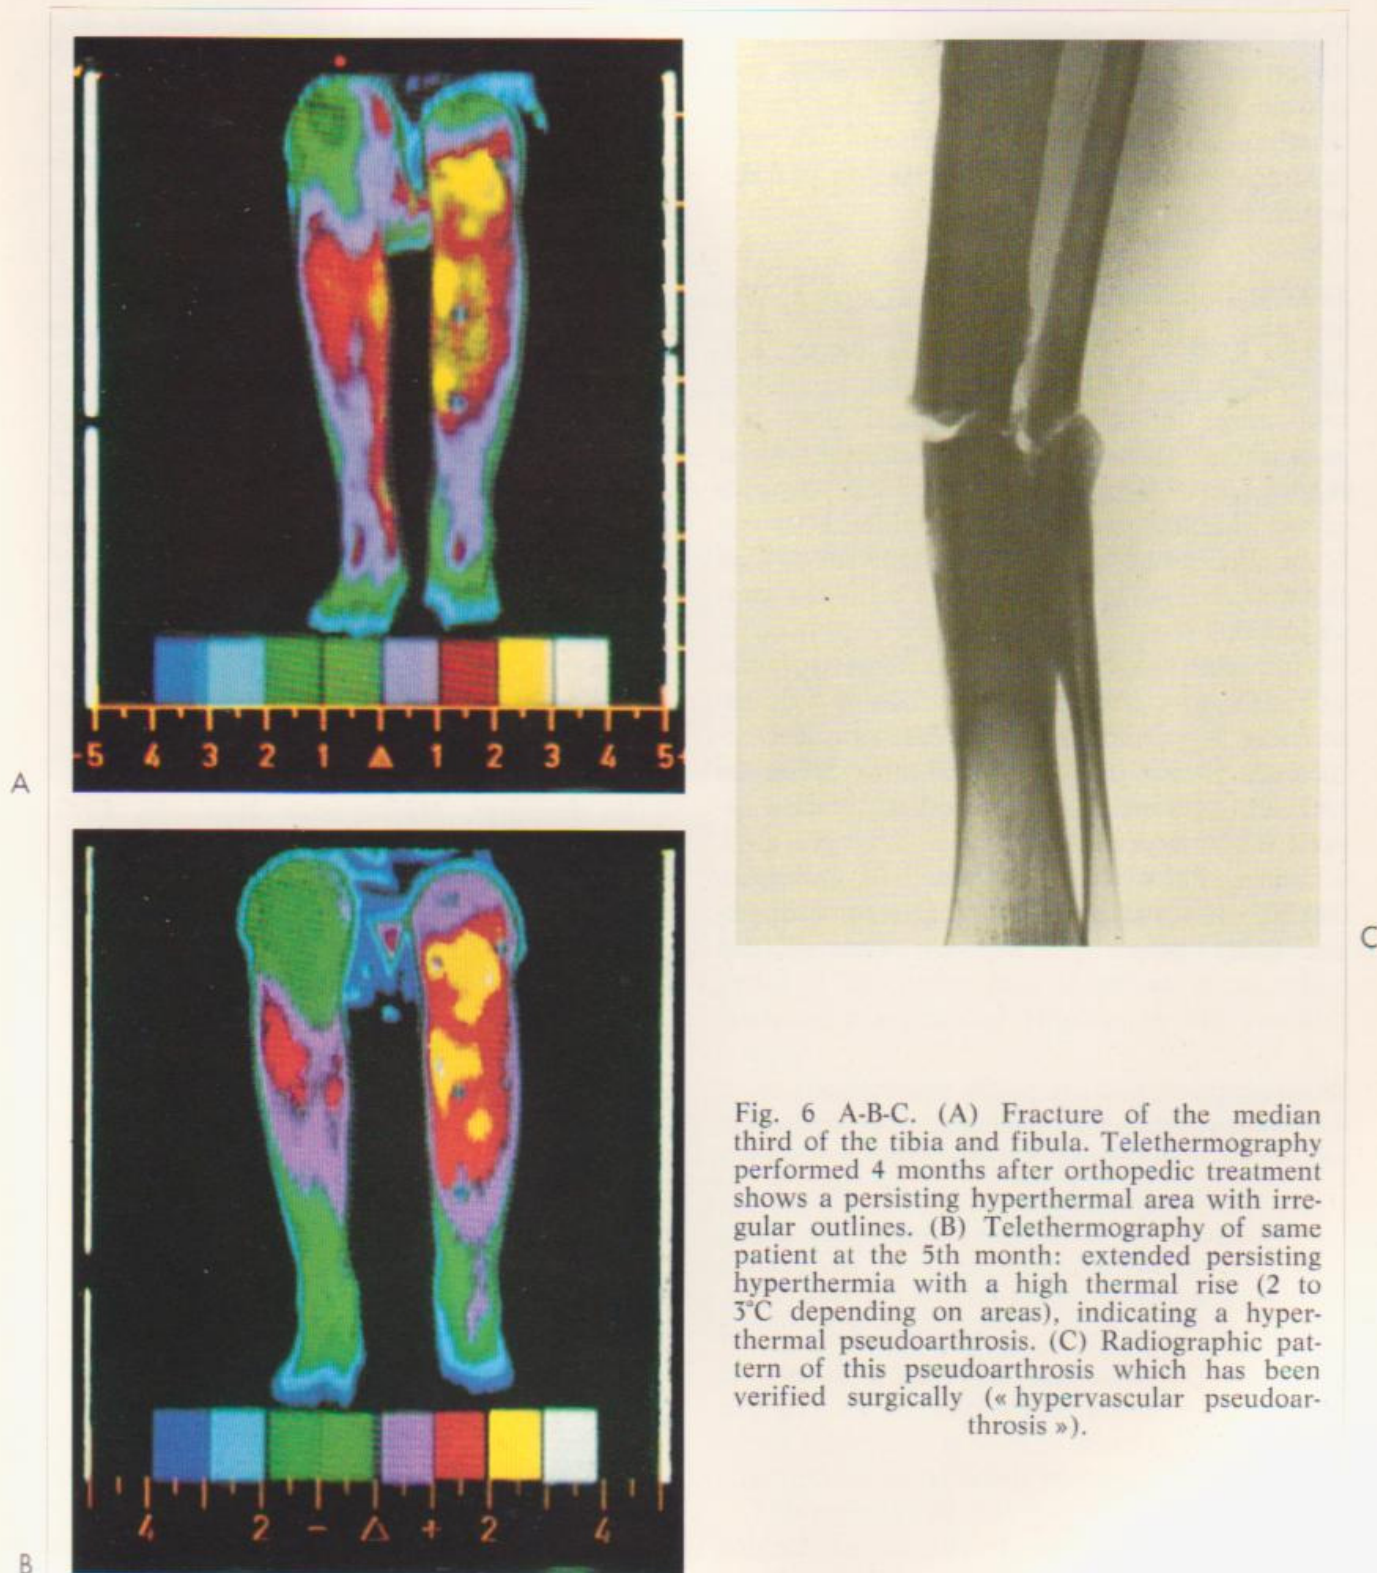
A-B-C. (A) Fracture of the median third of the tibia and fibula. Telethermography performed 4 months after orthopedic treatment shows a persisting hyperthermal area with irregular outlines. (B) Telethermography of same patient at the 5th month: extended persisting hyperthermia with a high thermal rise (2 to 3°C depending on areas), indicating a hyperthermal pseudoarthrosis. (C) Radiographic pattern of this pseudoarthrosis which has been verified surgically (« hypervascular pseudoarthrosis »).
